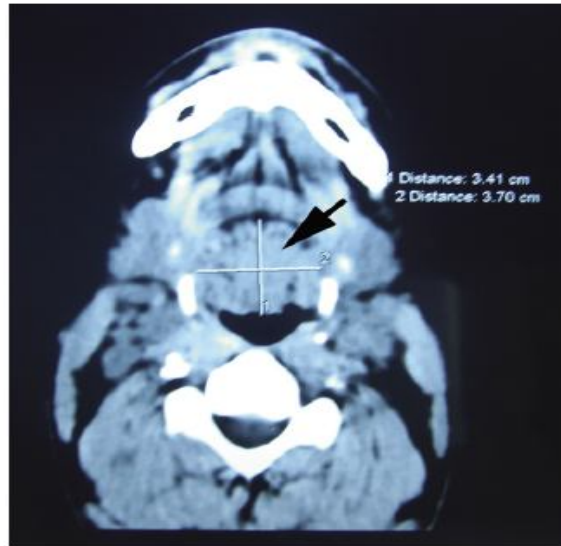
CT axial section, the arrow points to hypertrophied lingual tonsils.
